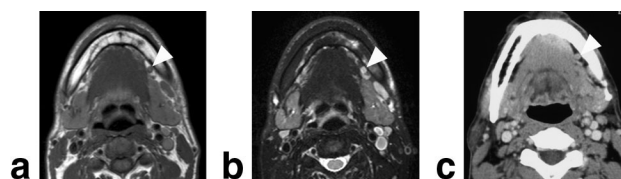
A 46-year-old woman with carcinoma in the lower gingival. a: Axial, T1-weighted image (TR/TE = 500 msec/15 msec) shows a small (4 mm in minimum axis diameter) reactive node (arrowhead) with intact hilar structure at level IB of the neck. Note small focus filled with fat tissue signals in node. b: Axial, fat-suppressed T2-weighted image (TR/TE = 4677 msec/80 msec) shows hypointense focus in the same reactive node (arrowhead) as in a. c: Axial, contrast-enhanced CT shows the same reactive node (arrowhead). Note that a small water-density area in this reactive node is barely distinguishable from focal defect on CT. Therefore, a small water-density area of a node on CT as shown in these cases (Figs. 4, 5) may be focal defect indicative of metastatic cancer focus or hilum structure in reactive node. These two distinctive areas are more readily differentiated by MRI.
